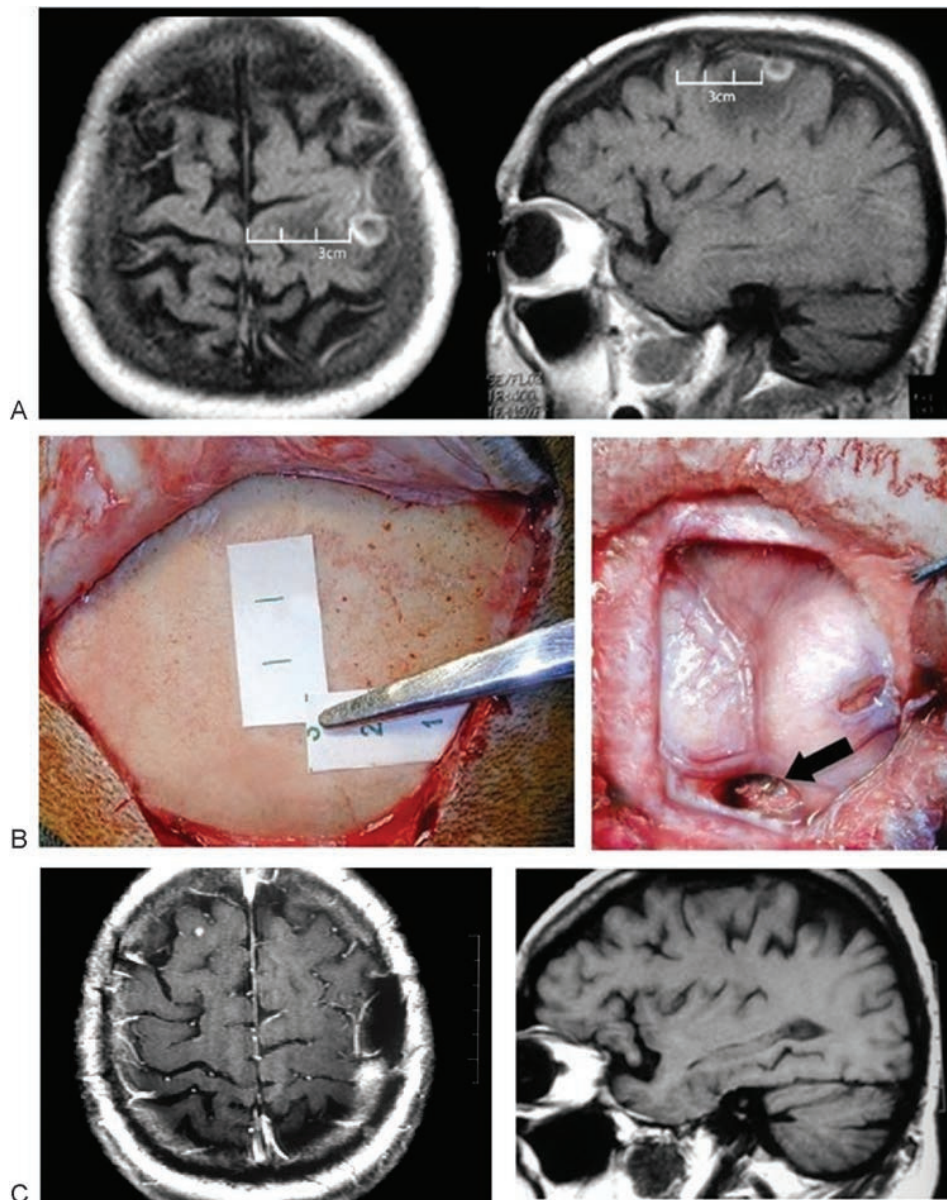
(a) Axial and sagittal MRI of a 42-year-old patient presenting with metastasis in the pre-central gyrus. (b) Craniotomy planning based on the relationship of the coronal suture with the central lobe and surgical aspect after surgical resection. In this case, the lesion was located 3cm posterior to the coronal suture and 3cm lateral to the midline. The use of auxiliary methods was not necessary. (c) Postoperative MRI showing total removal of the tumor. The patient recovered without manifestations of any motor deficits.
